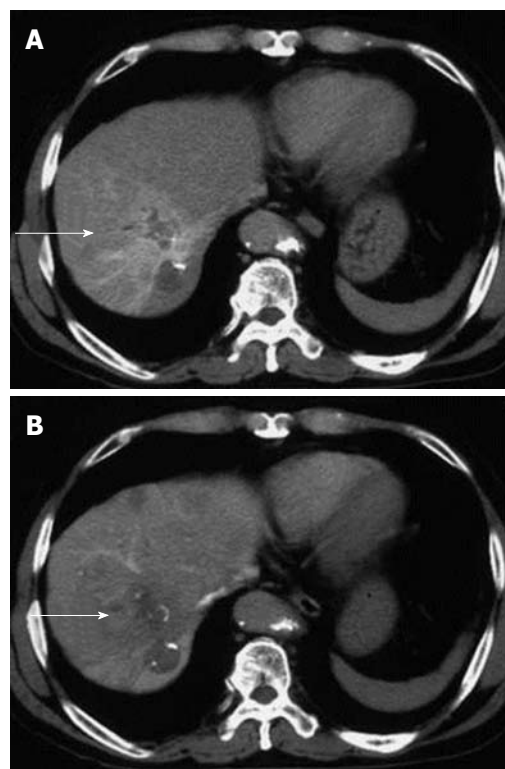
An abdominal computed tomography angiographic scan, showing a diffuse high-density area. A: An abdominal computed tomography angiographic scan including a lesion previously treated by radiofrequency ablation in segment 8 of the right hepatic lobe, in the arterial phase (arrow); B: The area was washed out on late-phase images (arrow).
